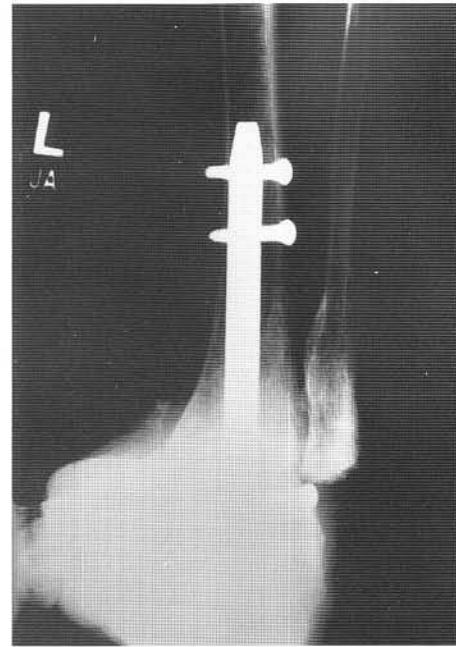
Postoperative A-P radiograph showing the intramedullary rod in place. Note the proximal and distal transfixation screws.
